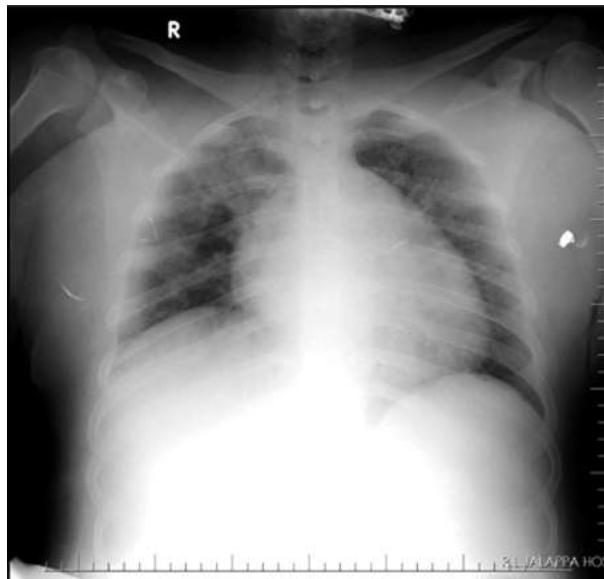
X-ray showing Dilated Cardiomyopathy.
